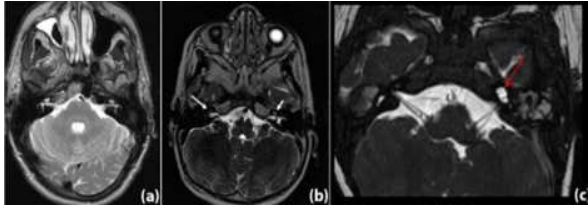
The temporal bone MRI demonstrating (a) patent cochlea, (b) obstructed cochlea, and (c) Cochlear anomaly (common cavity).
